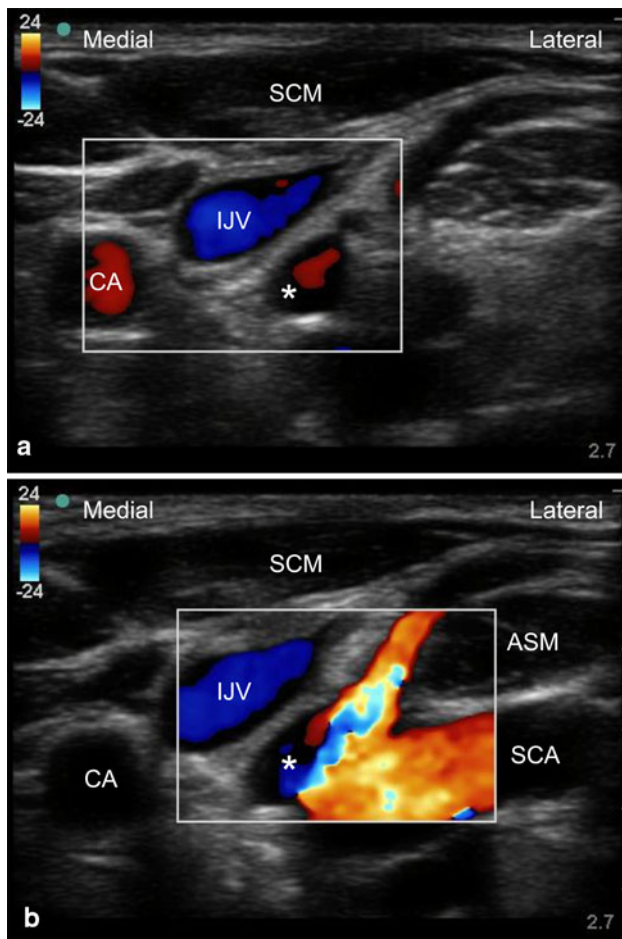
Transverse color Doppler ultrasound imaging of the internal jugular vein and the carotid artery at a level of about 3–4 cm cephalad to the clavicle (a) and slightly caudal to a (b). CA Carotid artery, IJV internal jugular vein, SCA subclavian artery, SCM sternocleidomastoid muscle, ASM anterior scalene muscle. Asterisk indicates an artery other than the carotid artery immediately posterior to the IJV. The artery immediately posterior to the IJV is derived from the subclavian artery and has a branch running anterior to the anterior scalene muscle (b)
